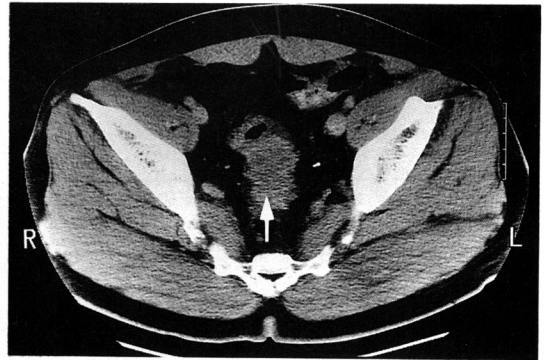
CT scan of the pelvis shows soft tissue mass (arrow) in the upper rectum.
